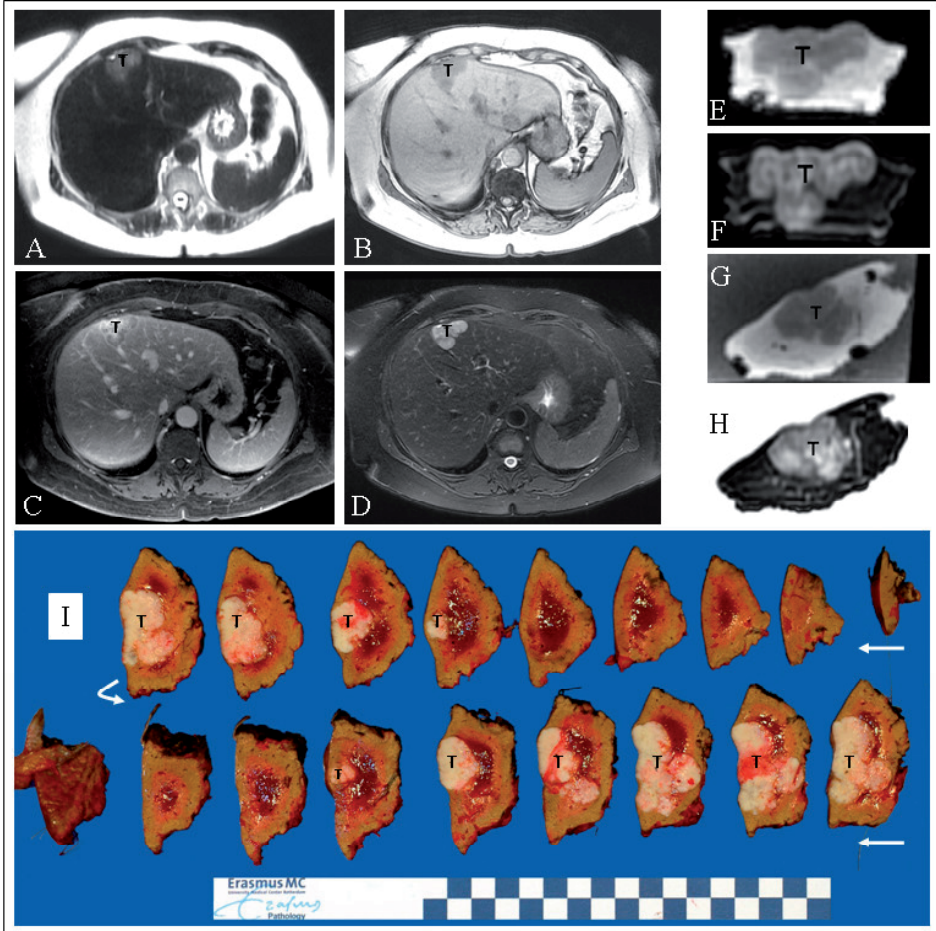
Magnetic resonance imaging series and macroscopic pathology corresponding to a patient with a colorectal liver metastasis located in segment 4. Tumor is represented by T.
